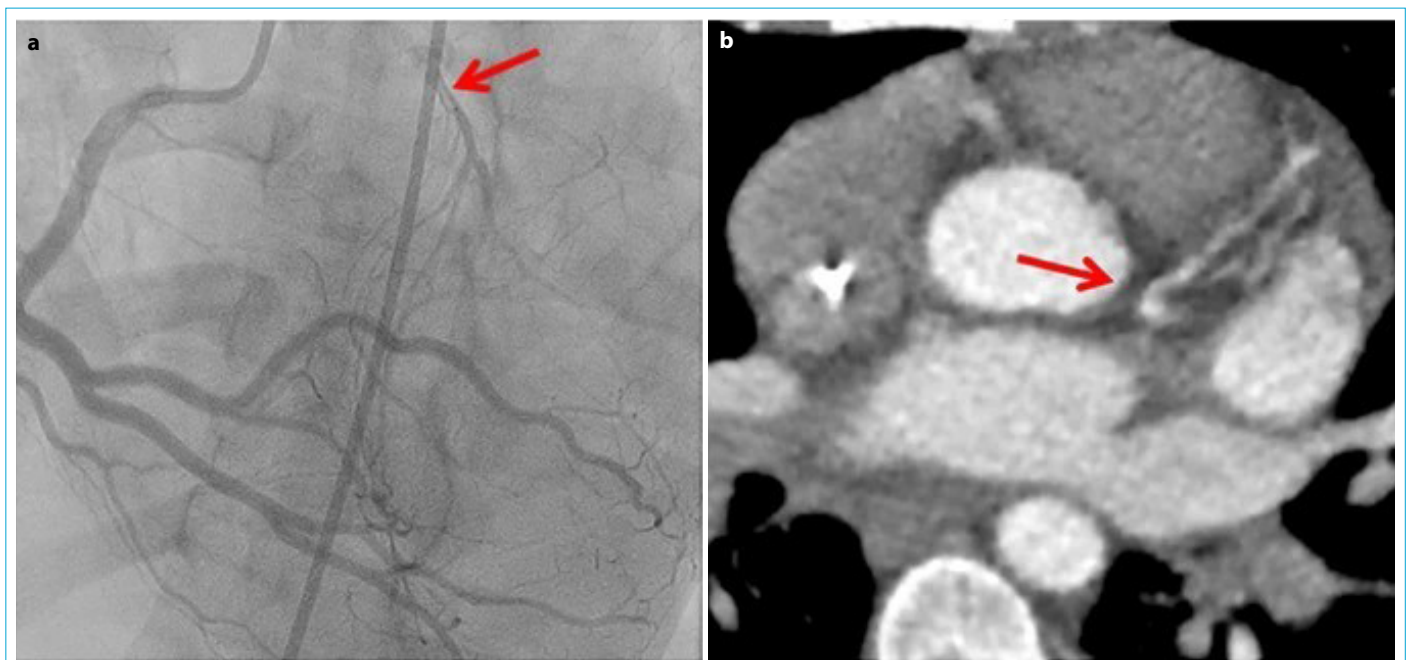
(a) A coronary angiogram shows the dissection within the lumen of the left anterior descending artery (LAD) was observed. The LAD was filling retrogradely from the right coronary artery, but no antegrade filling was observed. (b) The computed tomographic angiogram shows that no flow in the proximal left main coronary artery and the ostium of LAD, and findings consistent with dissection were detected in the LAD.
